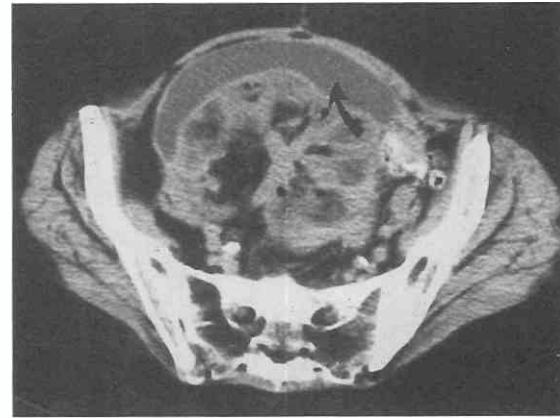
CT scan of a patient with primary papillary carcinoma of the peritoneum. There is a fluid density anteriorly (*arrow*), which represents a neoplastic loculation.
